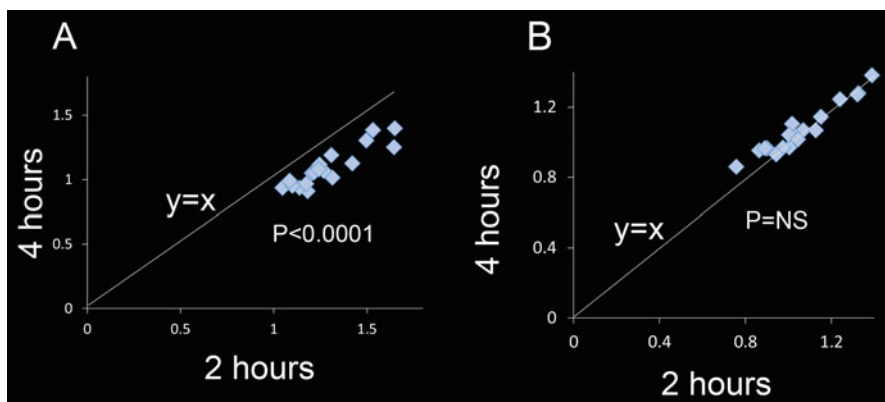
SUV of (a) gray and (b) white matter at 2 h vs. 4 h
